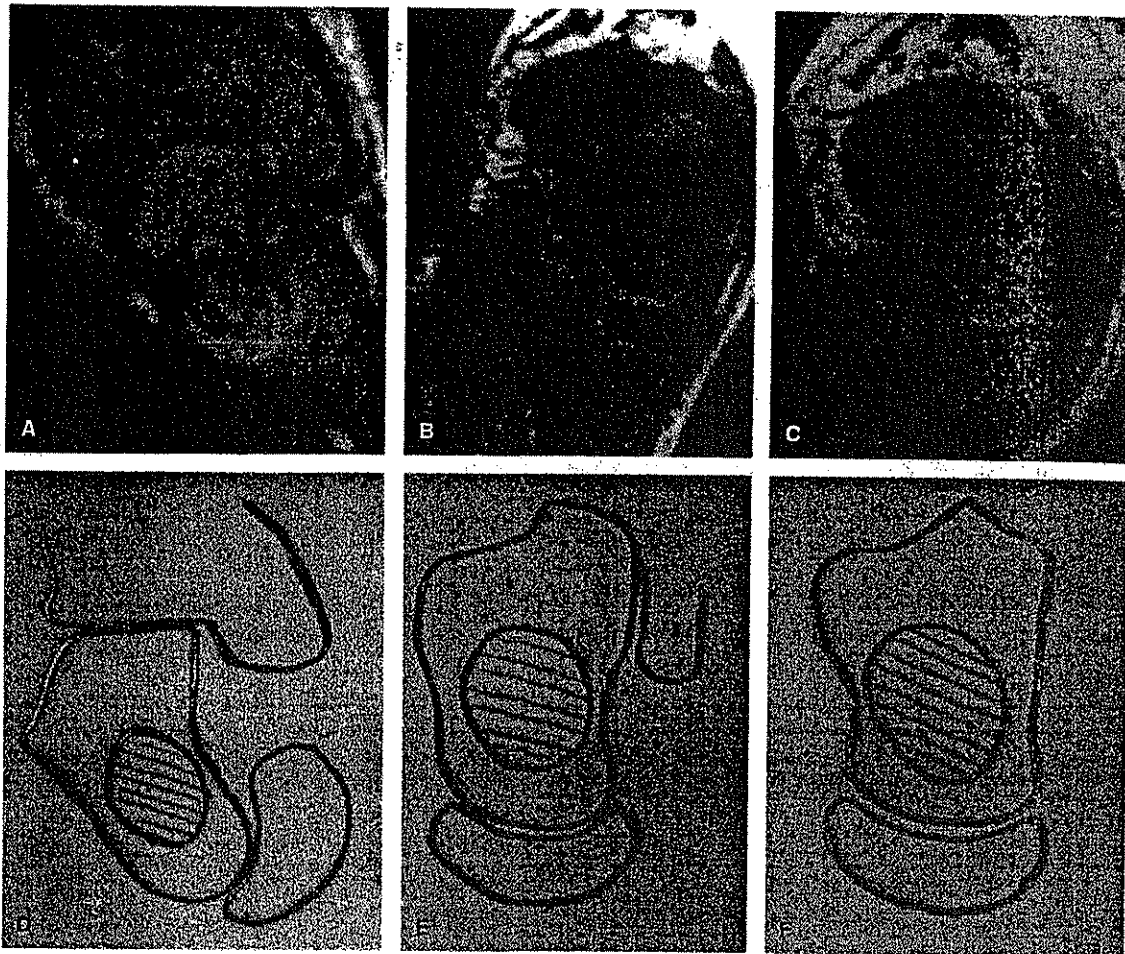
Patient 2. Sequential oblique axial magnetic resonance images perpendicular to the talonavicular joint show progressive correction of the medial talar neck inclination, the medial talonavicular displacement, the wedge-shaped head of the talus, and the wedge-shaped navicular from the first cast (A) to the fourth cast (B) to the seventh cast applied after percutaneous tenotomy (C). In the seventh cast, the medial talar inclination was reduced to normal and the talonavicular joint was reduced anatomically and was congruent. D-F: Tracings of the correction of the medial talar neck inclination and the medial talonavicular displacement.
